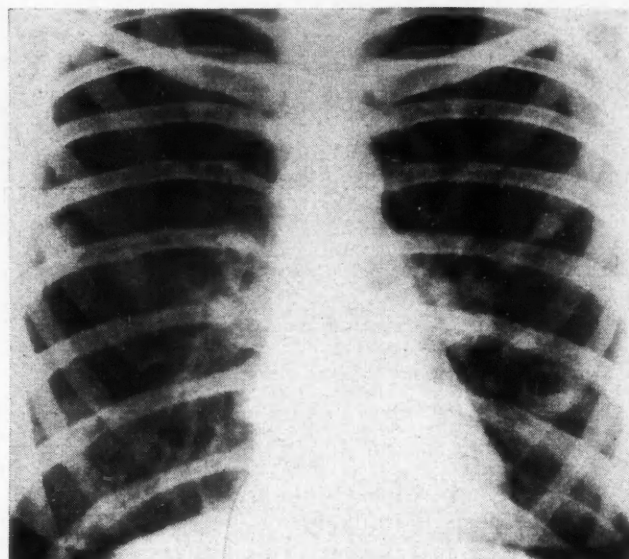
Chest roentgenogram taken May 25, 1951.
